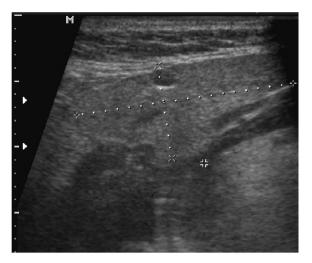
Ultrasound image showing anteroposterior length and paramandibular depth.
